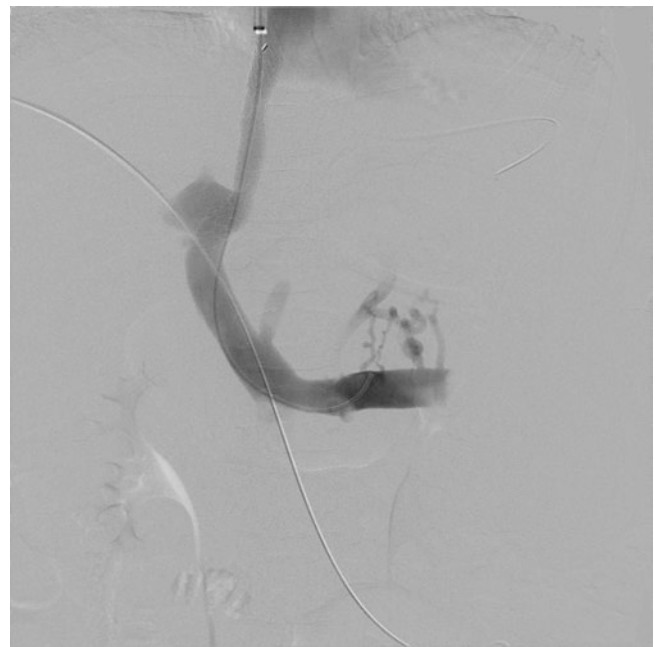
A transjugular intrahepatic portosystemic shunt (TIPS) is a tract created within the liver using x-ray guidance to connect the hepatic vein with the portal vein. The shunt is kept open by a stent and is useful to reduce portal pressure in intractable variceal bleeding
